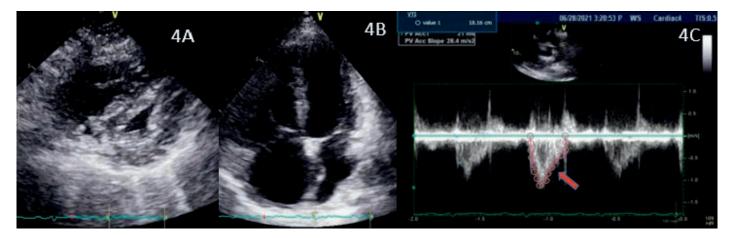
(A) Hyperdynamic LV and systolic interventricular septal flattening. (B) RV enlargement and dysfunction, RA dilatation and right-toleft interatrial septal bowing. (C) PW Doppler of the RVOT. Short acceleration time and late systolic notching (red arrow). LV, left ventricular; PW, pulsed-wave; RA, right atrial; RV, right ventricular; RVOT, RV outflow tract
